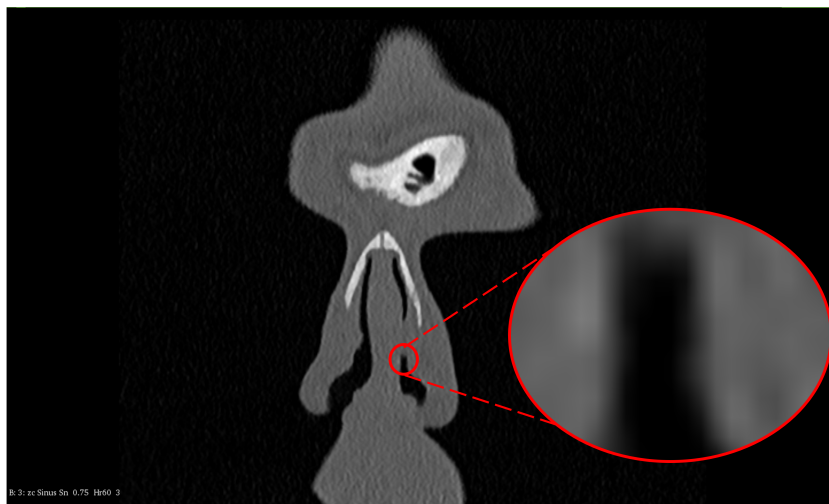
A slice of scan2 CT scan image along anterior-posterior direction (same location as figure 3.1 (a)). If we zoom in on the nasal airway boundary, the grayscale of the boundary is gradually changing. This is because the resolution of the CT scan imaging will never be accurate enough to determine the exact location of the boundary between air and its surrounding structures. Therefore, a range of grayscale is specified for the threshold filter to detect the airway boundary.
